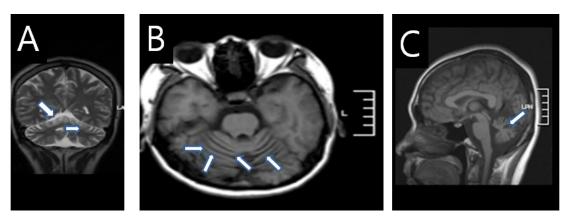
Brain magnetic resonance imaging of Patient 2
